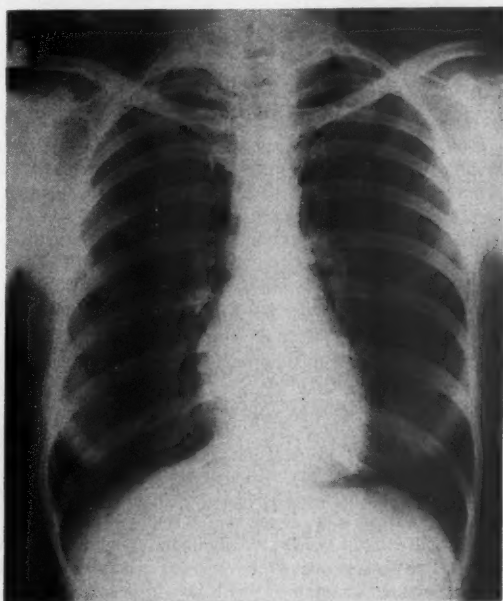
Roentgenogram taken October 1951, showing clearing, although patient still symptomatic.
